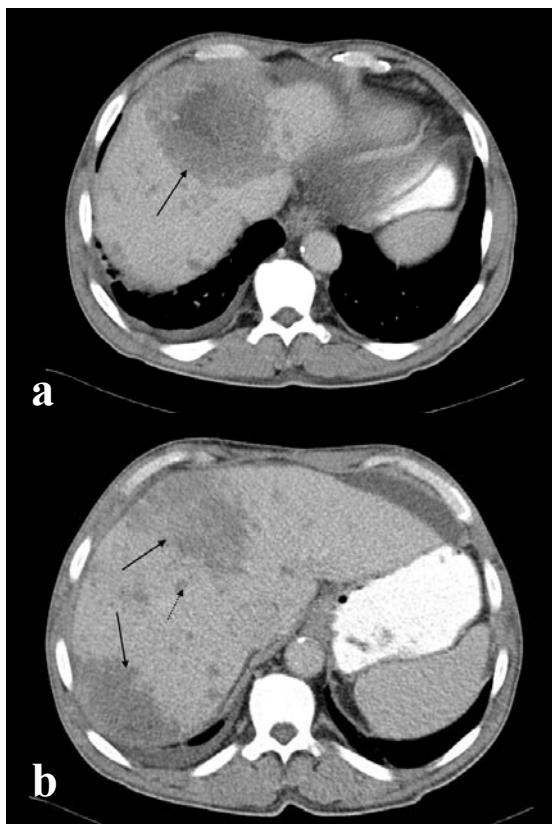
CT scan after 4 months of PEG IFN treatment. Hypodense focus in segment 8 with diameter 98 mm (fig. 3a) and focuses in segment 4 and 6 with diameters of 85 mm (fig. 3b – solid arrows). Secondary focuses (dashed arrows).
